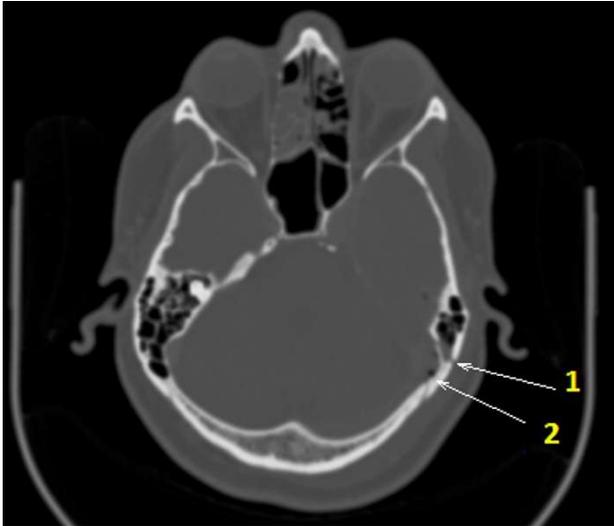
Axial view of computed tomogram of temporal bone showing fracture (1) and pneumocephalus (2)
